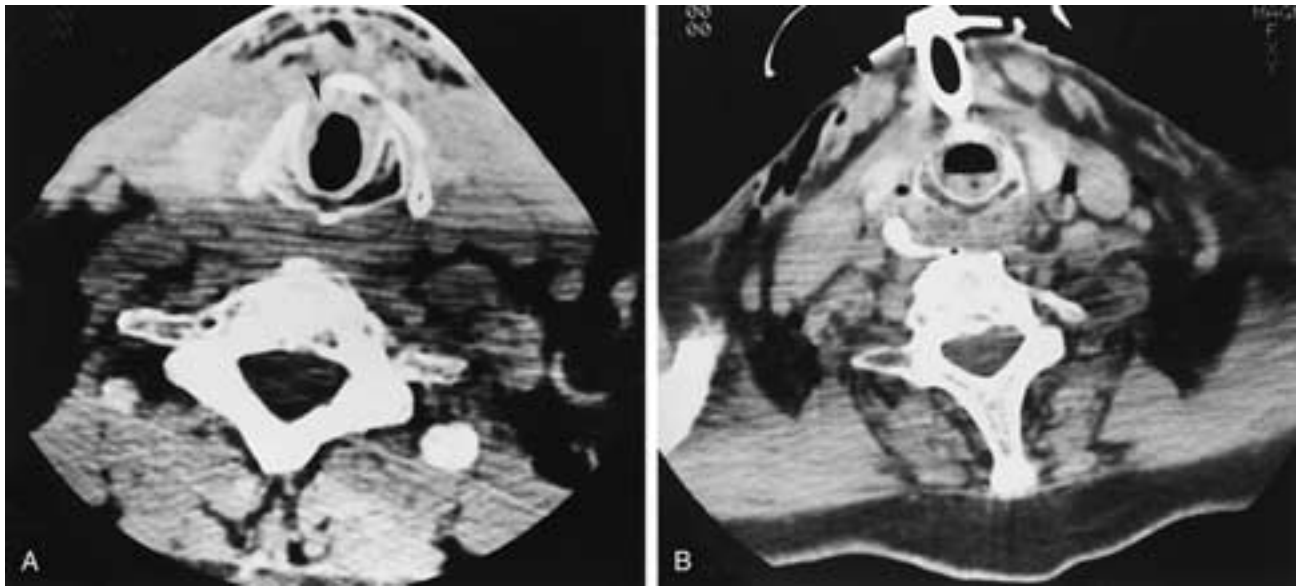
A, Tracheostomy tube. Axial CT scan through the cricoid shows swelling in the subglottic region (*arrowhead*) caused by recent tracheostomy placement. This can mimic tumor. B, Scan through the cricoid shows the extratracheal portion of the tracheostomy tube and an air-fluid level in the trachea.
